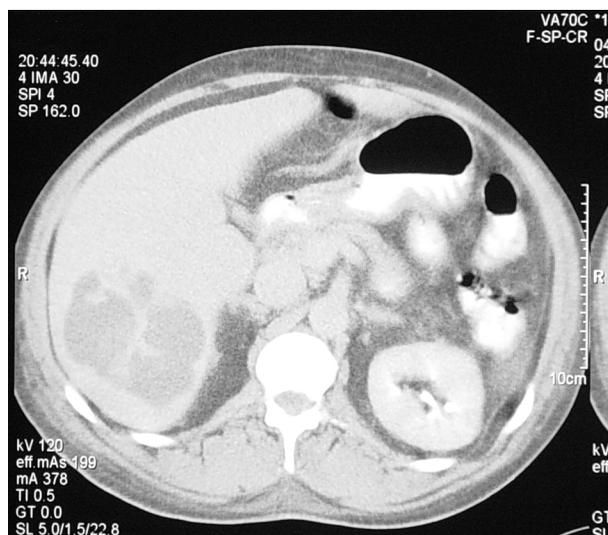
Abdominal computed tomography scan of the case patient demonstrating a liver mass.
